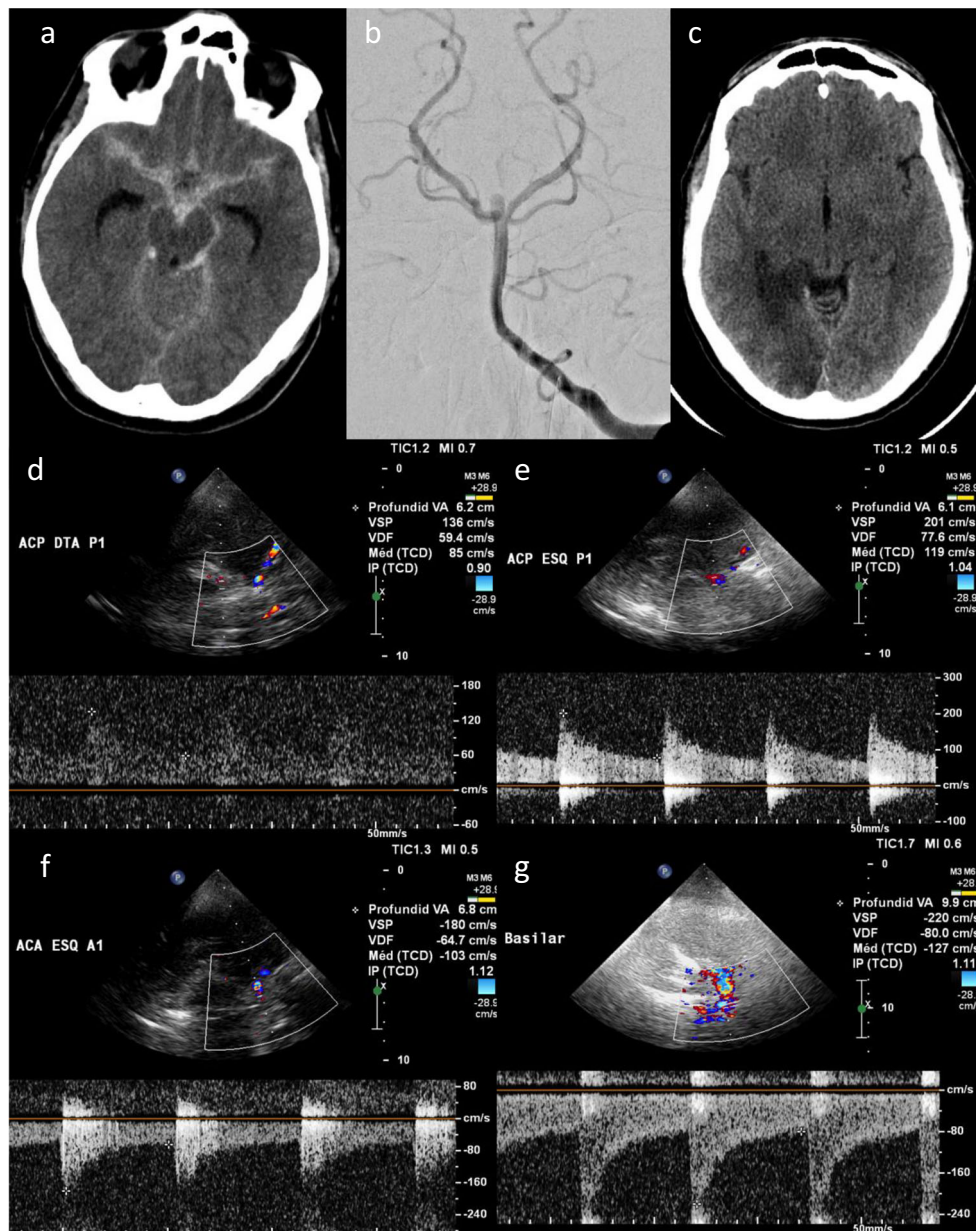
Thirty-nine-year-old male with a ruptured basilar tip aneurysm that later developed vasospasm and cerebral infarct. CT scan at admission showed a diffuse modified Fisher grade 3 SAH (a), and DSA performed at admission (b) showed normal diameter vessels and a basilar tip aneurysm. CT scan repeated at day 7 post-SAH (c) shows an acute ischaemic infarct on the right PCA vascular territory. Same day TCD study shows increased mFV of the right PCA P1 segment (d), 85 cm/s, left PCA P1 segment (e), 119 cm/s, left ACA A1 segment (f), 103 cm/s, and basilar artery (g), 127 cm/s, suggestive of moderate vasospasm of the PCA P1 segments and left ACA A1 segments, and moderate to severe vasospasm of the basilar artery
